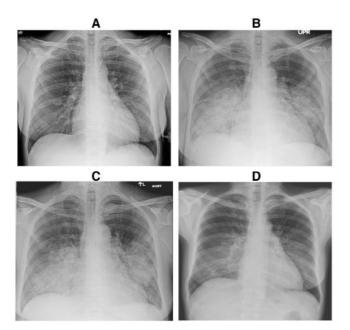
AP chest radiograph of a patient with TRALI. (A) Pretransfusion chest radiograph shows normal lungs; (B and C) Post-transfusion chest radiographs taken 5 and 40 hours after transfusion showing alveolar opacity with perihilar predominance in the bilateral mid and lower zones of the lungs; (D) Chest radiograph 72 hours after transfusion shows improvement in lung opacity.¹⁸
